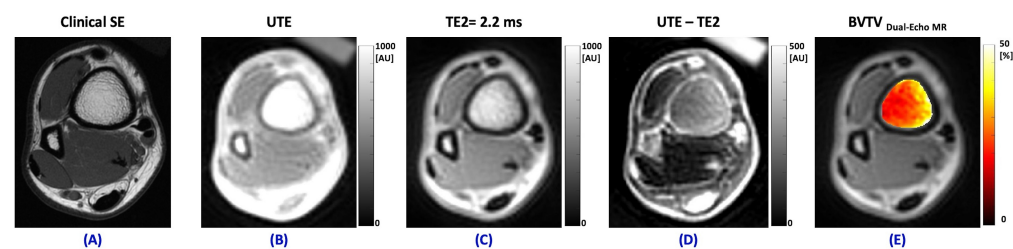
(A) Clinical axial T1 weighted spin echo sequence (TR = 788 ms, TE = 8.31 ms), (B), UTE-MRI (TE = 0.032 ms), (C) second echo MRI image at TE = 2.2 ms, (D) subtracted second TE signal from the UTE signal (representing the decayed bone signal), and (E) $BVTV_{\text{Dual-Echo MR}}$ map (calculated from Equation (1)) of the distal tibia in a 24-year-old healthy male volunteer in the axial plane.
